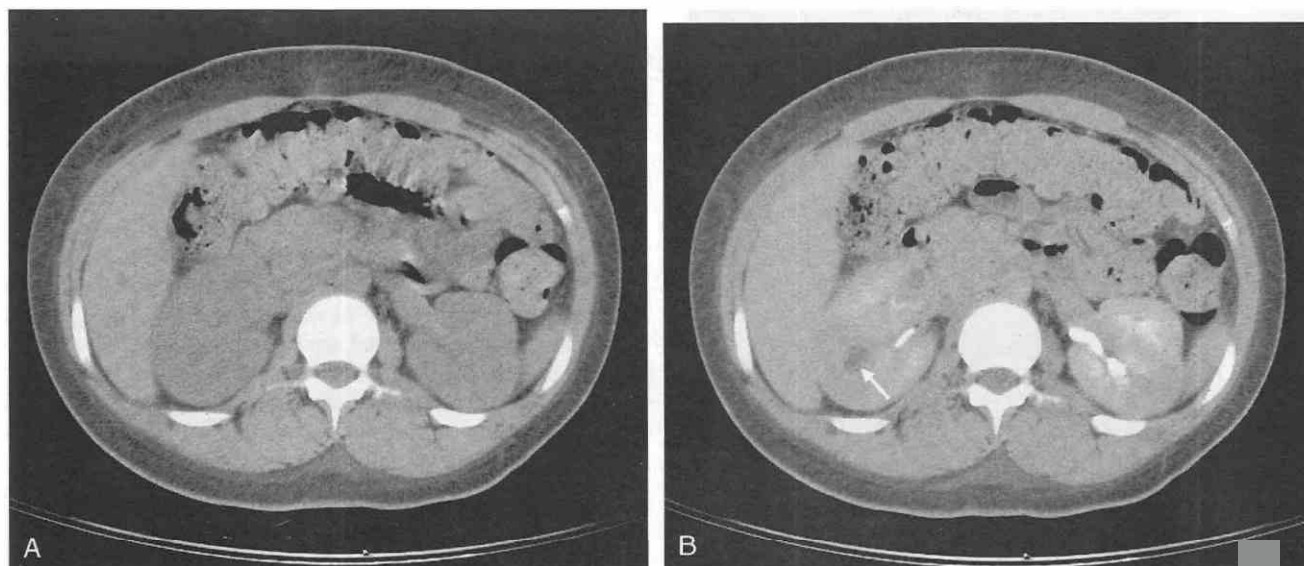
Abscess. The importance of administering IV contrast material. *A*, Before administration of contrast material, the CT scan shows no visible abnormality. *B*, After administration of intravenous contrast material, the CT scan shows enhancement of the renal parenchyma, but the abscess exhibits very low density and a clearly defined margin (*arrow*).
